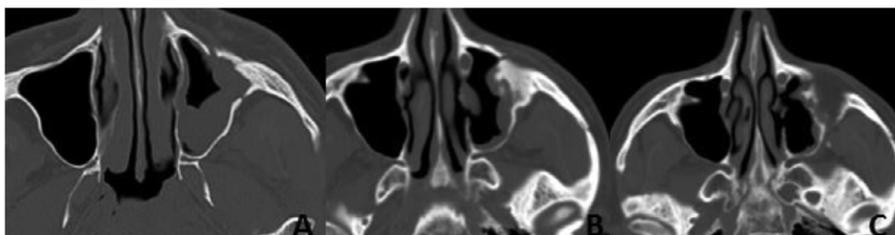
Computed tomography (CT) examination. A 30-year-old woman repeatedly hit to the face with multiple fractures of the left maxillary sinus associated with hem sinus and ipsilateral zygomatic arch fracture (A-C).
